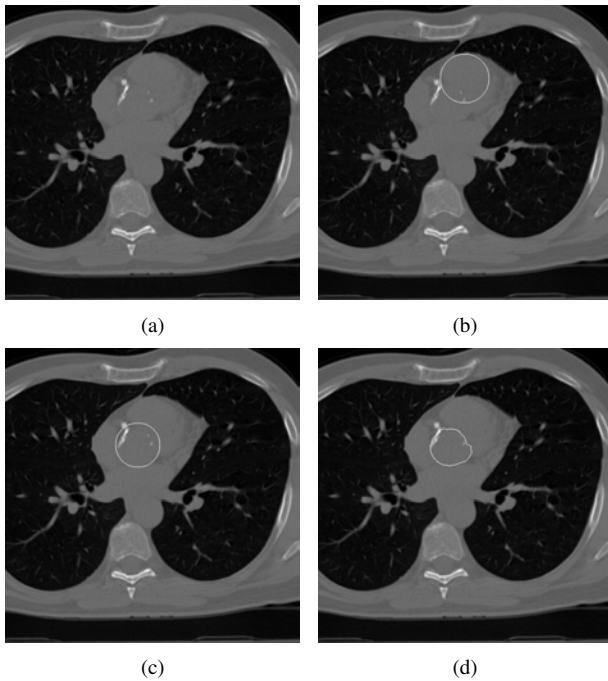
(a) Original CT image, (b) aorta detected from global maximum in Hough space, (c) aorta detected using dynamic programming in Hough space, and (d) aorta boundary contour detected using dynamic programming.
